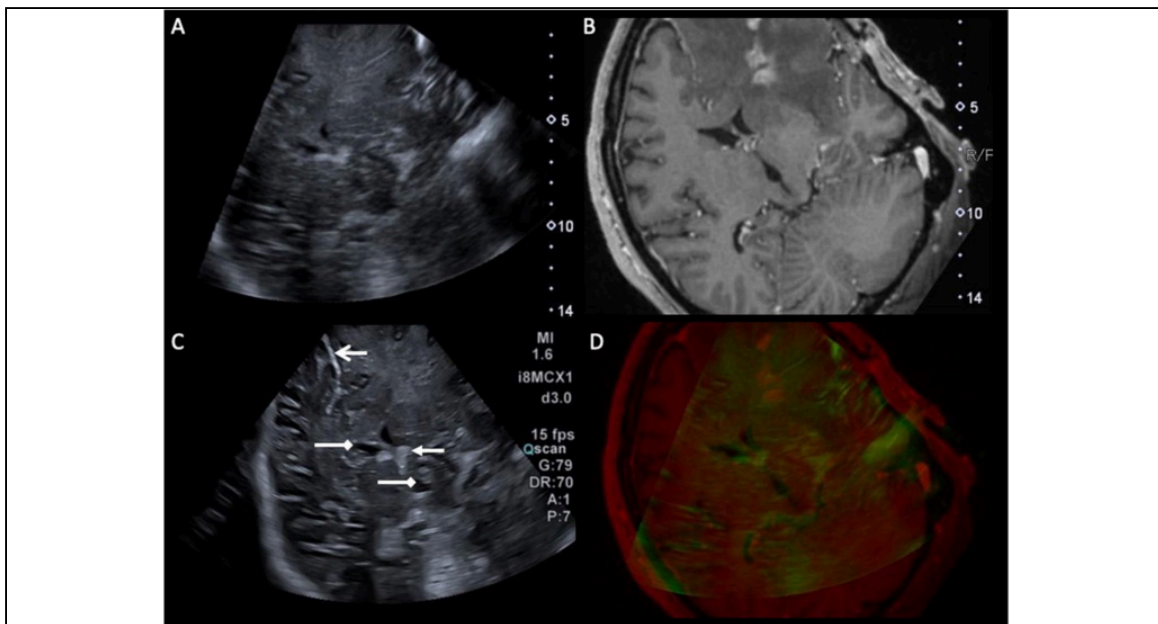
Navigated 3D US with MRI fusion example, and anatomical landmarks for orientation (falx cerebri, ventricles, choroid plexus)
